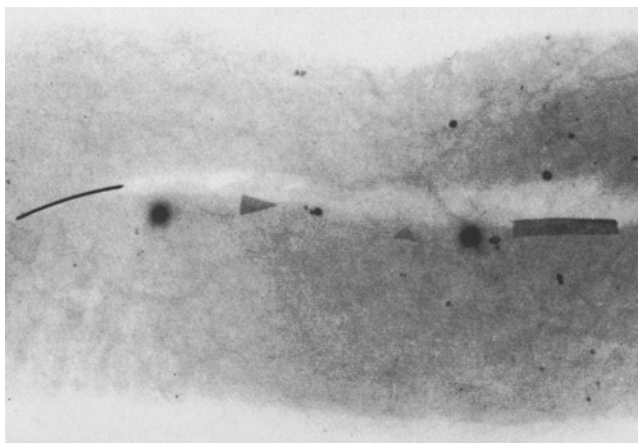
Particles of acrylic paint (low energy X-ray imaging). For comparative purposes 2 steel balls (diameter 1 mm) are included
